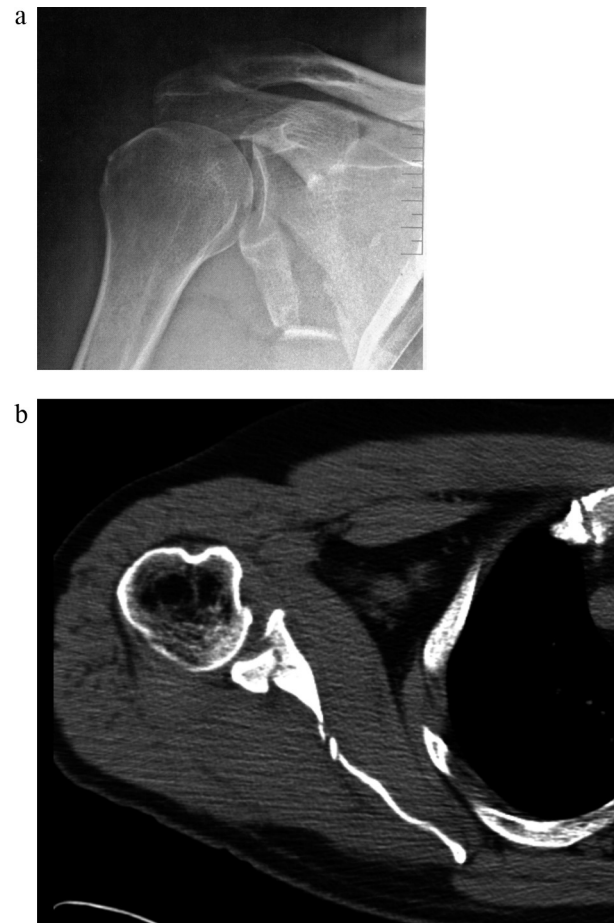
a.p. X-ray of the right shoulder (a) and CT-scan (b) of a 34-year-old female after a fall onto her extended right arm: type II glenoid fracture according to Ideberg.
